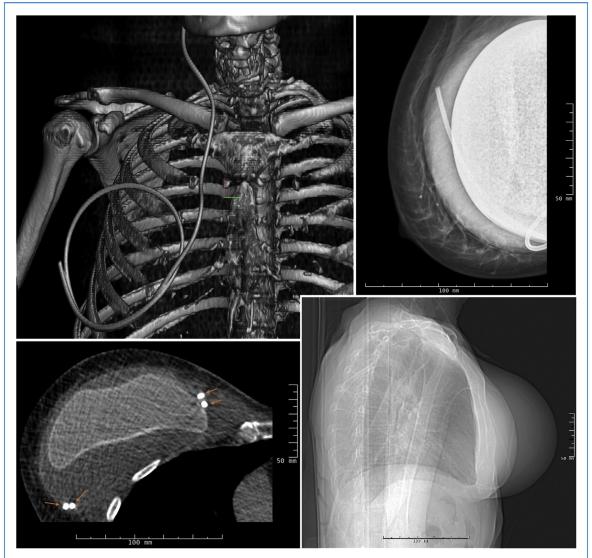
A 69-year-old woman with bilateral breast implants and a newly inserted ventriculoperitoneal shunt due to normal pressure hydrocephalus presented with a 4-day history of swelling of the right breast. Ultrasound and a mammogram (*top right*) showed fluid surrounding the breast implant along with radiopaque tubing. A huge discrepancy between her breasts was observed on the computed tomography (CT) scout image (*bottom right*). The CT scan (*bottom left*) showed that the distal catheter (DC) (*orange arrows*) had migrated
